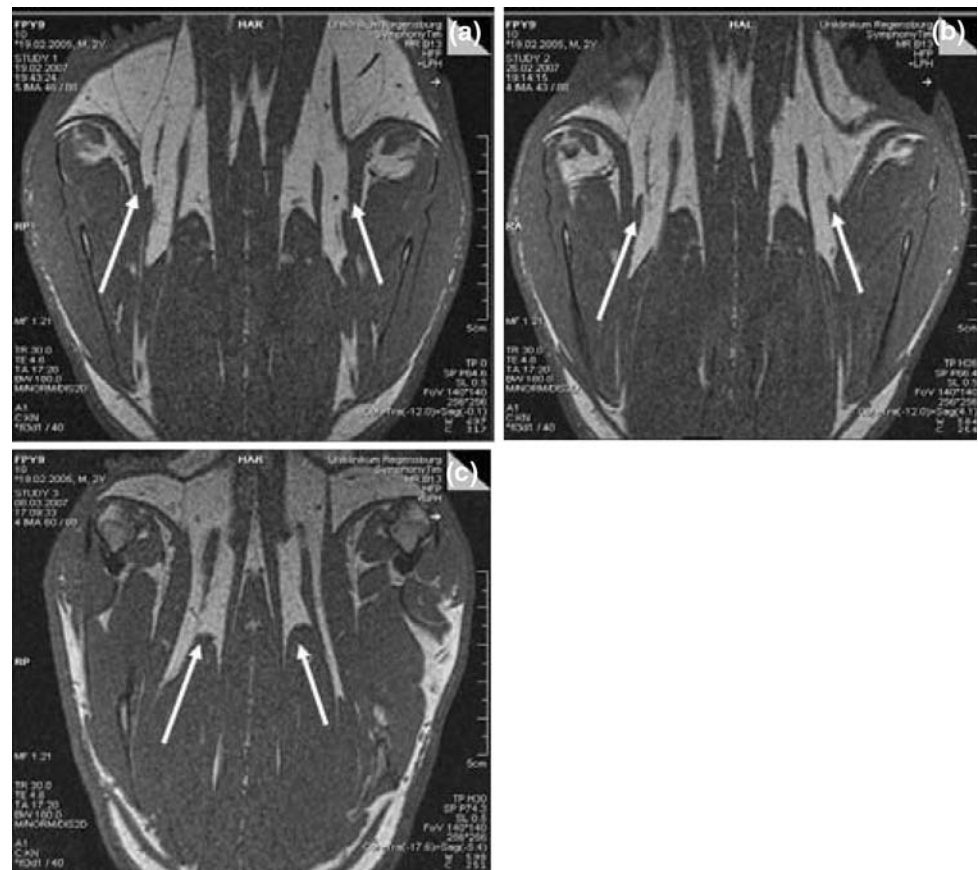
Magnetic resonance imaging (MRI) of the corpus adiposum interscapulare (a) before, (b) 10 days after, and (c) 3 weeks after local lipolysis. Sagittal imaging shows the volume reduction effects after lipolysis (arrows)
